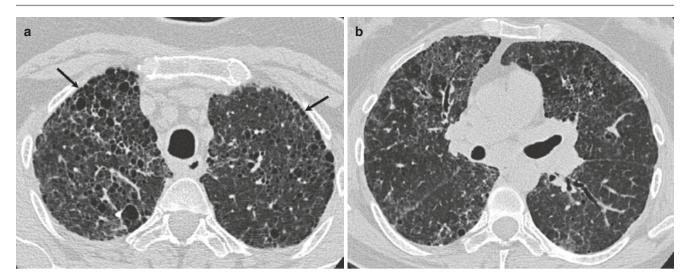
CT pattern indeterminate for UIP despite honeycombing. (a, b) Axial CT images show honeycombing (arrows), but there is extensive cyst formation in the central lung associated with GGOs; hence the pattern was called as indeterminate for UIP. UIP was proven at biopsy
